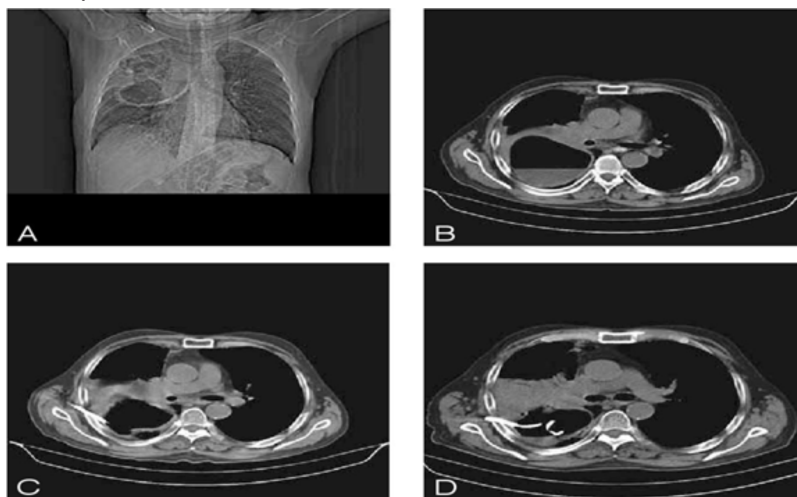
A 60 year old man with right lung abscess and failed medical treatment. Figures 3. (A,B.) Chest radiograph and CT scan (mediastinal window) show a cavitary lesion with air-fluid level almost filling the right hemithorax representing an abscess. Fig 3 (C.) CT scan after percutaneous drainage shows immediate decrease in fluid and size of lung abscess. The patient had a rapid symptomatic response to abscess drainage. Fig 3 (D.) A Follow up CT scan 6 days after the procedure shows almost
